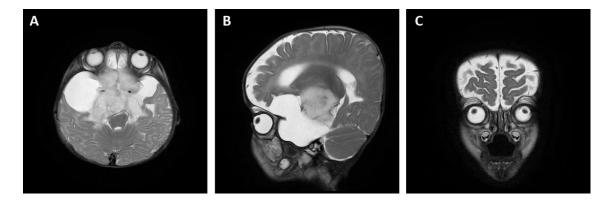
T2-weighted axial FSE (A), T2-weighted sagittal FRFSE (B) and T2weighted coronal FRFSE (C) magnetic resonance images confirm the brain tumour. The images also show the upward deviation of the eyes.
